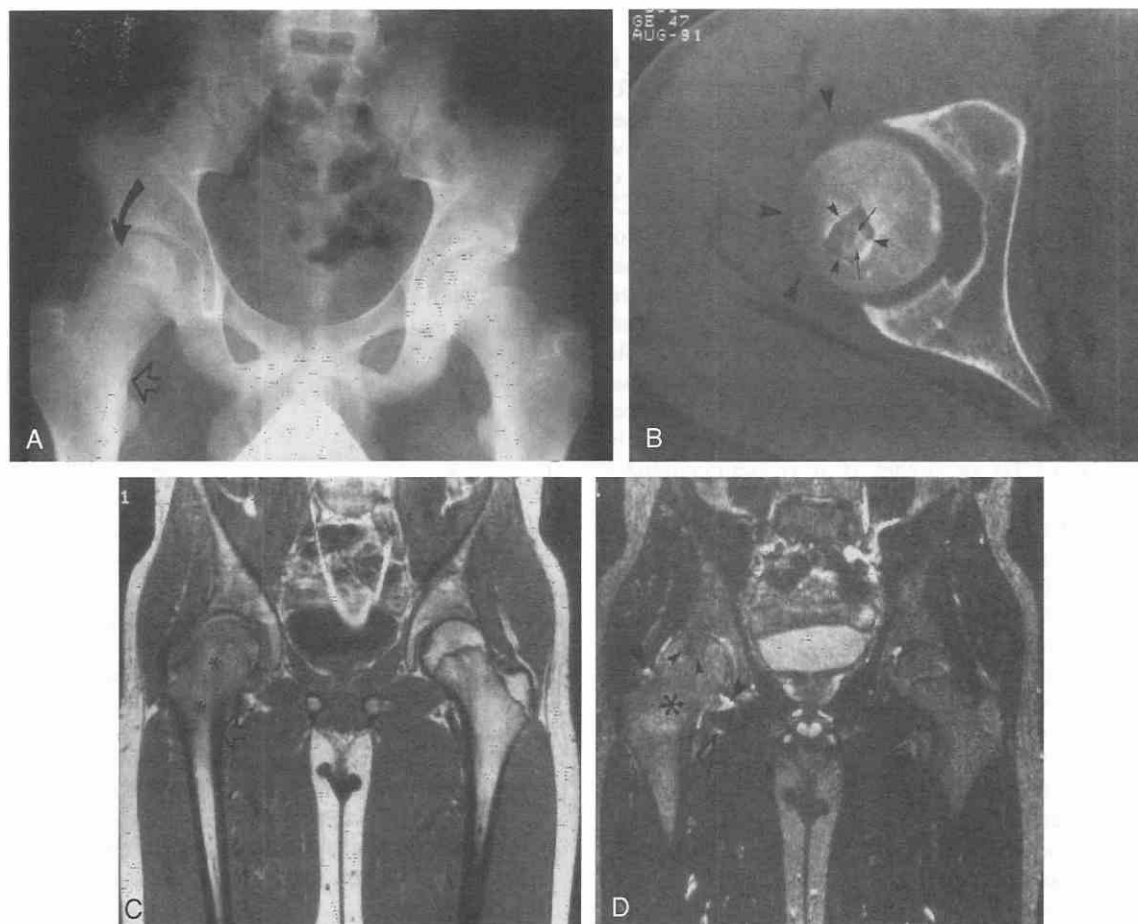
Chondroblastoma of the right femoral head in a 14-year-old boy after several months of hip pain. A, Pelvic radiograph shows deformity of the right femoral head with a periosteal reaction in the medial femoral neck (open arrow). The lytic lesion (curved arrow) is difficult to detect. B, CT scan reveals the lytic lesion (small arrowheads) with surrounding sclerosis and chondroid matrix within the chondroblastoma (arrows). Joint effusion is also identified (large arrowheads). C, Coronal T1-weighted MR image reveals diffuse marrow replacement in the right proximal femur (asterisks) with the chondroblastoma difficult to distinguish as a focal lesion. Periosteal reaction is seen as increased signal intensity within the medial femoral neck cortex (open arrow). D, Coronal T2-weighted MR image shows diffuse, mildly increased marrow signal intensity in the right femur from edema (asterisk). The chondroblastoma shows low signal intensity (small arrowheads) resulting from chondroid matrix and high cellularity (confirmed by pathologic examination). Associated high-signal-intensity joint effusion (large arrowheads) and periosteal reaction (open arrow) are also seen.
